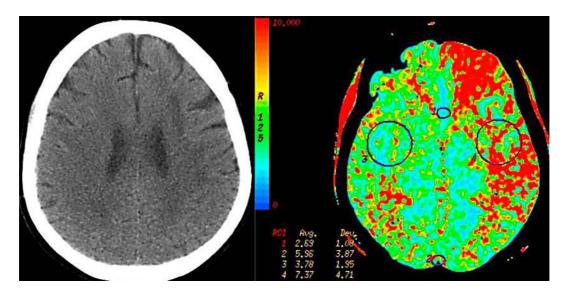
Cranial CT: left-sided white matter disease. Perfusion CT: mean transit time was markedly prolonged within the left MCA and ACA territories (7.4 vs. 3.8 s on the right territories).
